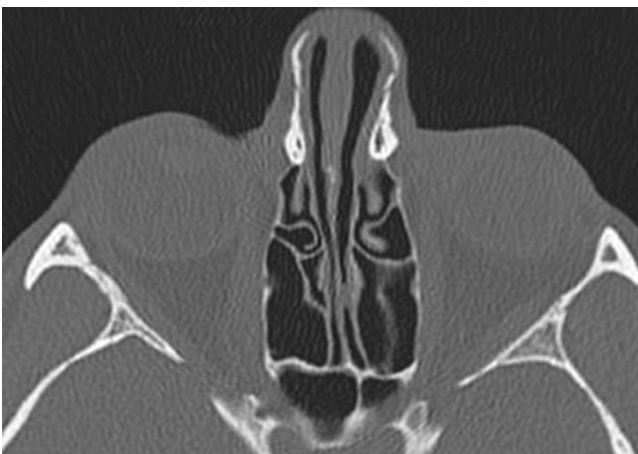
CT image of June 2016 showing no apparent asymmetry of the eyeballs.
